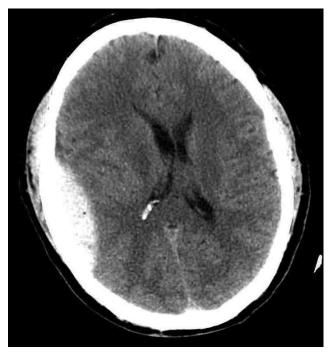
CT image of the brain.
